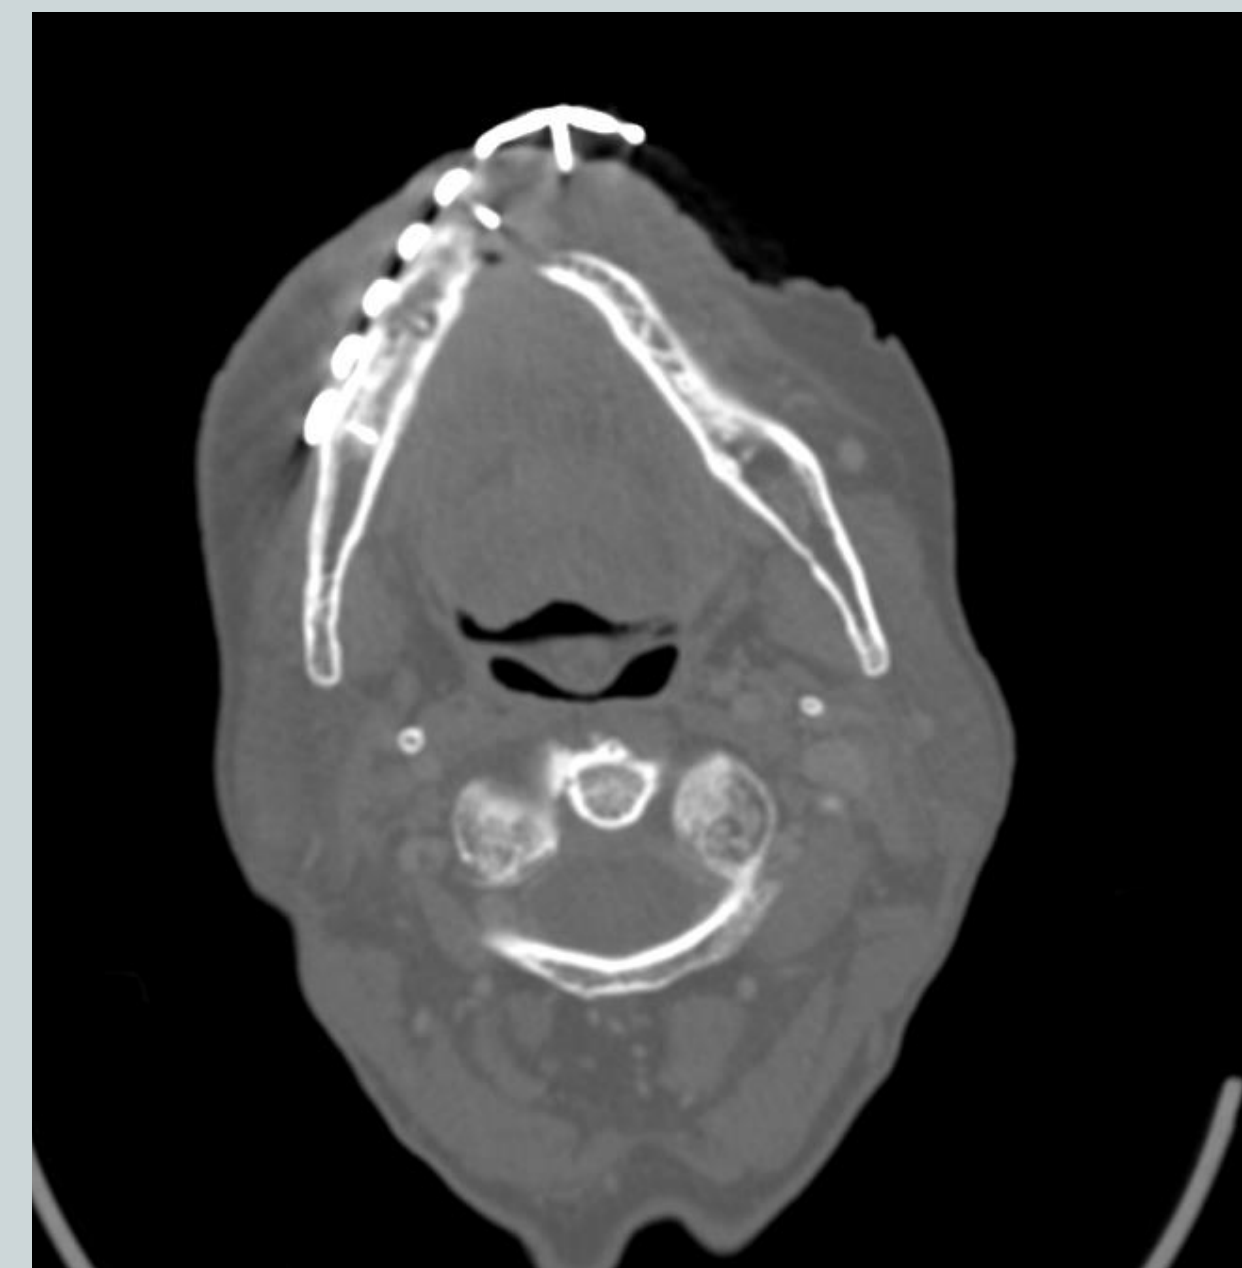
Axial CT study patient demonstrating pathologic parasymphyseal fracture and hardware extrusion.
